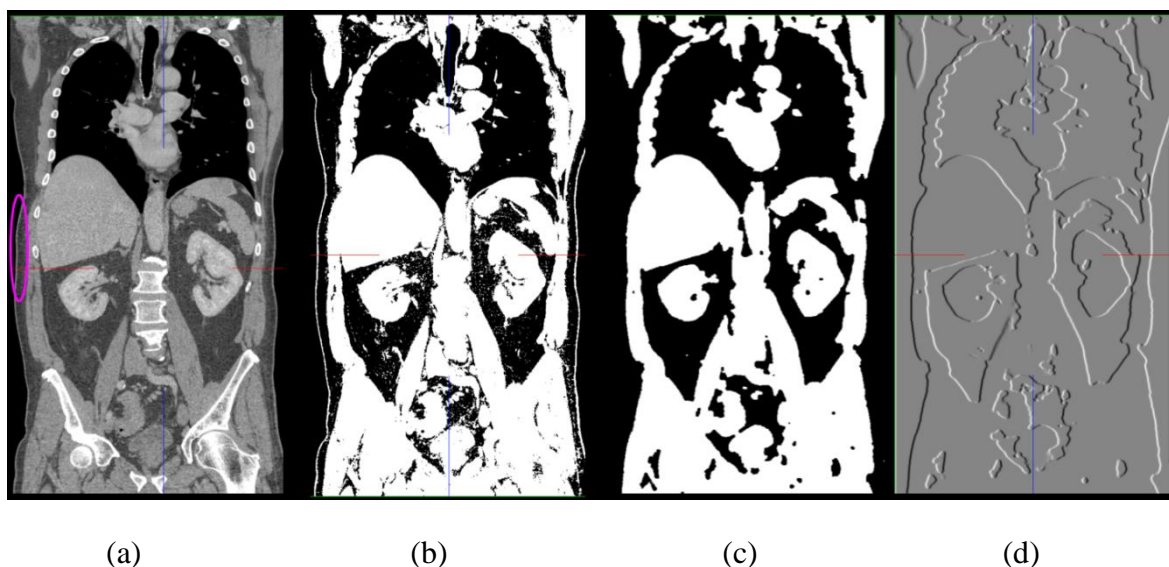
The segmentation of muscle border. (a) Original CT image in frontal view; (b) new image after the fat tissue removing;(c)New mask image without fat tissue and skin; (d) Magnitude image of the gradient in x direction.
